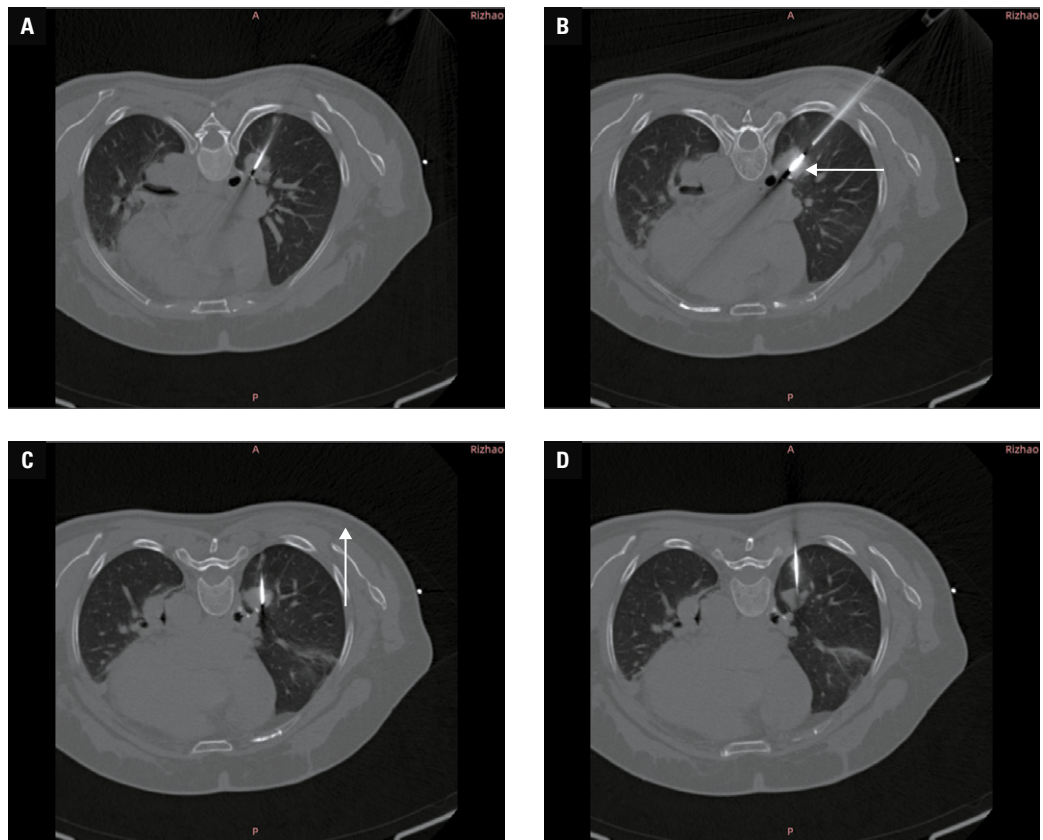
A–D – chest computed tomography performed during microwave ablation (MWA) combined with particle implantation showing insertion of the the MWA needle (B, arrow) and the particle implantation needle (C, arrow) into the target location, according to the preoperative plan
